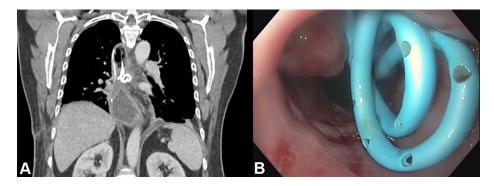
A, coronal computed tomography image of two double pigtail stents between the mediastinal abscess and the gastric lumen. B, Endoscopic view of two double pigtail stents in the gastric lumen, distal to the anastomotic staple line.
